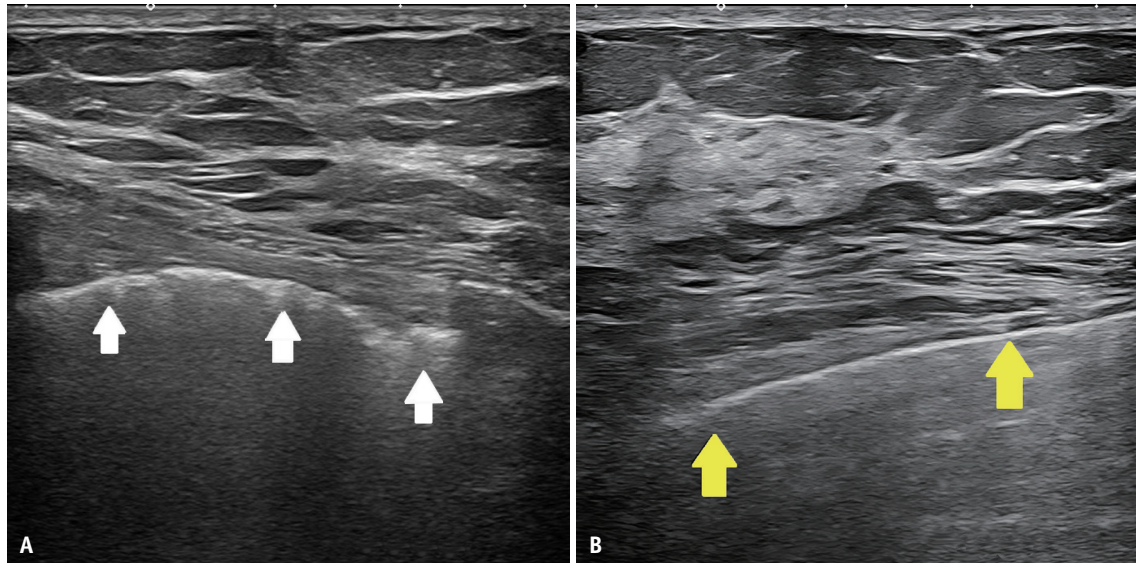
Radiation-induced pleural fibrosis. A, B: Ultrasound scans at 15 MHz. In the left breast (A), the pleural hyperechoic line is thick and irregular (white arrows). The pleura is thin and regular in the right non-irradiated breast (yellow arrows) (B).
